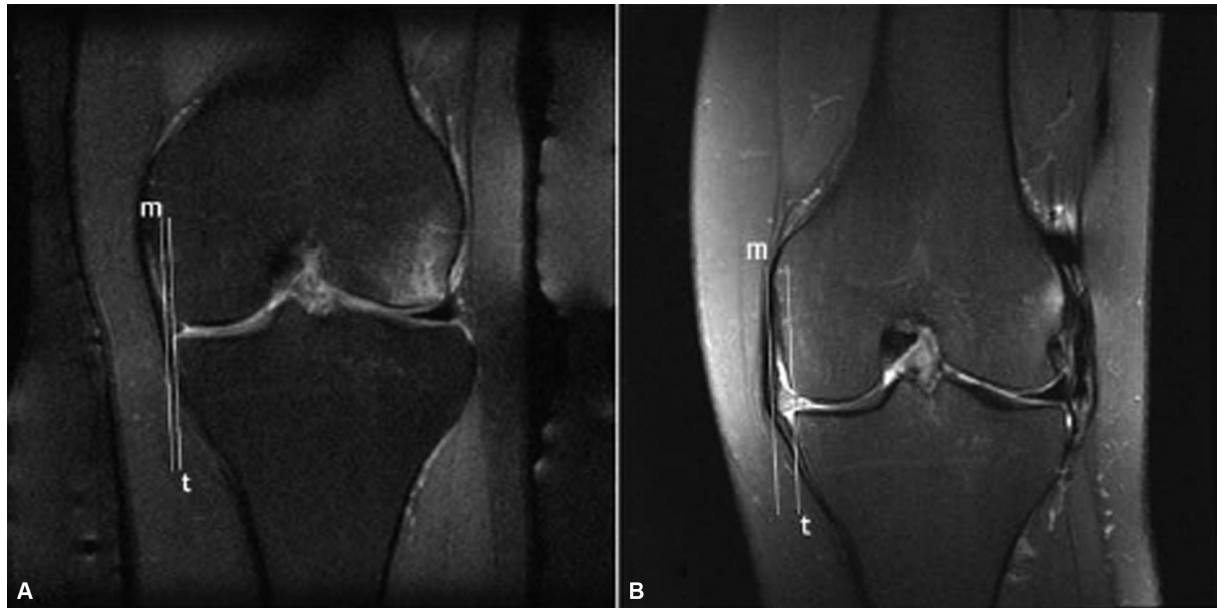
MRI of a left knee. (A) Preoperatively, meniscal remnant extrusion was 2 mm (minor extrusion) in this case. (B) The postoperative MRI used to calculate scaffold extrusion showed that the scaffold was 5 mm (major extrusion) beyond the tibial margin. m, meniscal remnant or scaffold border; MRI, magnetic resonance imaging; t, tibial margin.
